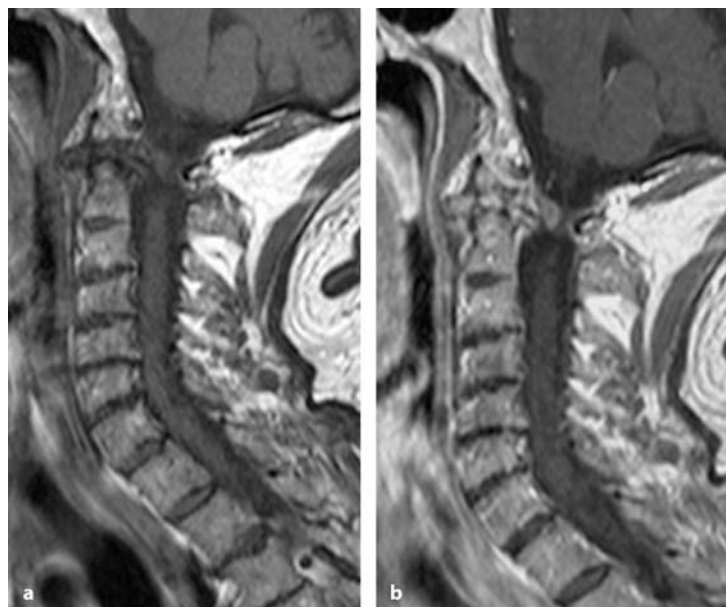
Sagittal (a) and axial (b) T1-weighted MRI scans of a synovial cyst at C2 on the left side in a 51-year-old man with a 2-year history of neck pain, diffuse sensory changes and dysesthesias on the left side. c The axial T2-weighted scan clearly demonstrates the extradural localization. d A CT scan shows the lesion as an isodense process. e This intraoperative view, taken with the patient in the semisitting position after hemilaminectomy of C2, shows the opened cyst. (Continuation see next page)
